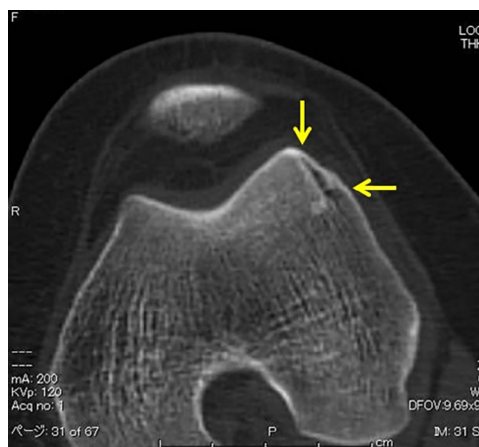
Follow-up 3-dimensional reconstructed computed tomography scan shows the donor site and bone formation (arrows).
